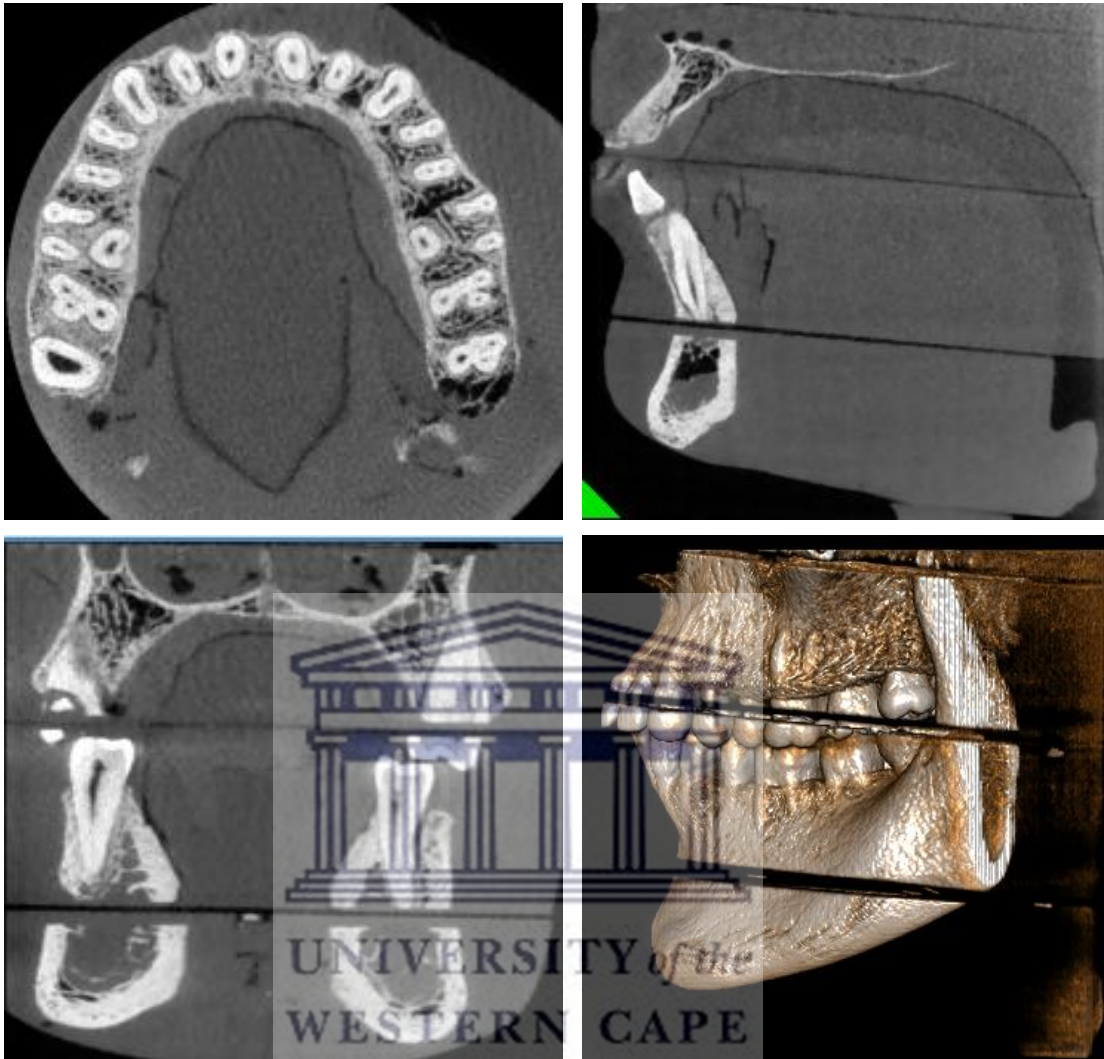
Axial slice (top left), sagittal slice (top right), coronal slice (bottom left), and 3D view (bottom right) reconstructed from the acquired CBCT volume (NewTom® 5GXL, FOV 8 × 8 cm, regular scan, and standard dose).
